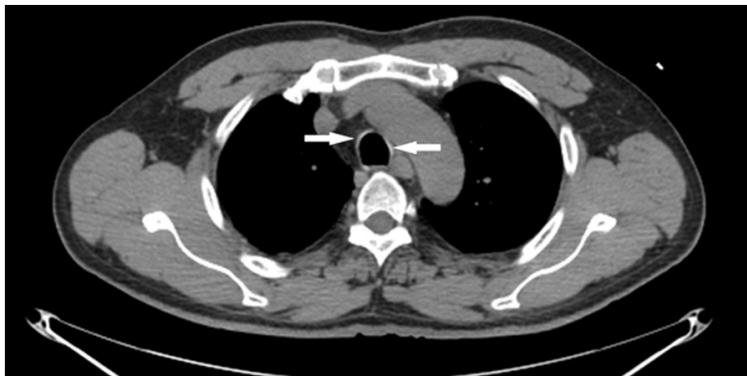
Chest high-resolution computed tomography (HRCT) scan revealed mild tracheal cartilage calcification (arrows).
